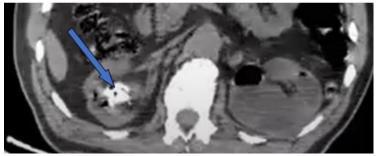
Axial section abdominal CT scan showing: Bilateral renal intra parenchymal gas bubble with appearance of pyelonephritis and right renal coralliform lithiasis (arrow)
